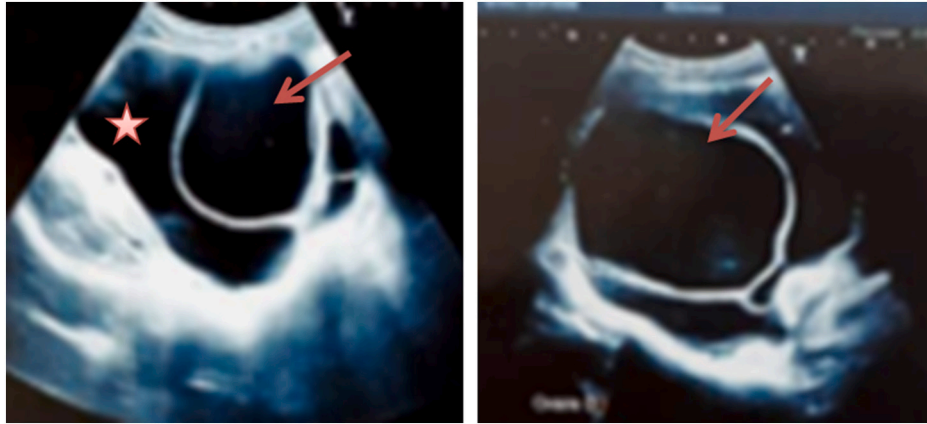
Ultrasonography: multilocular cystic mass of the left ovary (arrow) with ascites (star).
